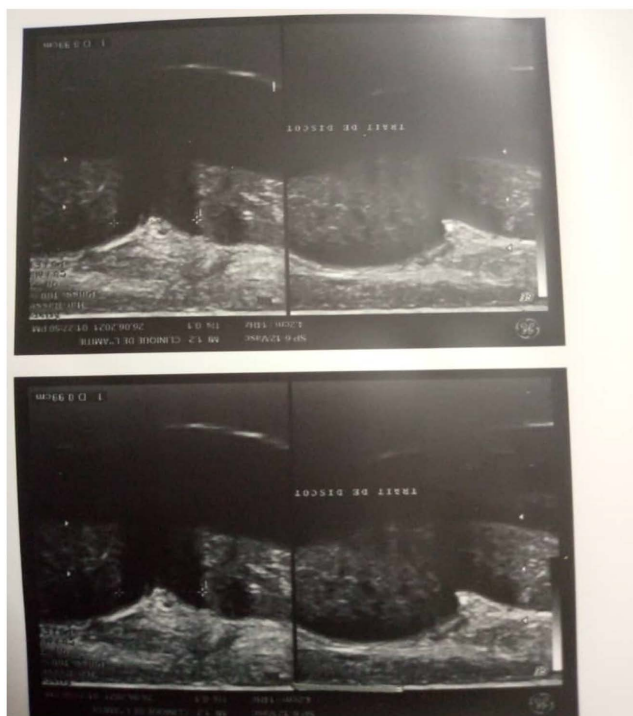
Ultrasound result.
